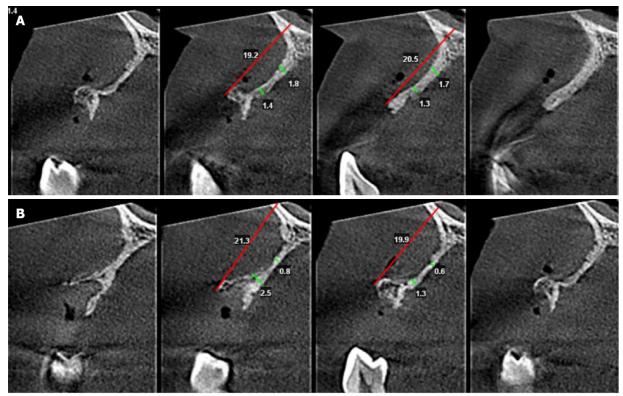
Bone volume at the defect area before bone grafting. A: Cone beam computed tomography (CBCT) before bone augmentation surgery 5 and 10 mm below the alveolar crest at the site of missing tooth 12; B: CBCT before bone augmentation surgery 5 and 10 mm below the alveolar crest at the site of missing tooth 14.
